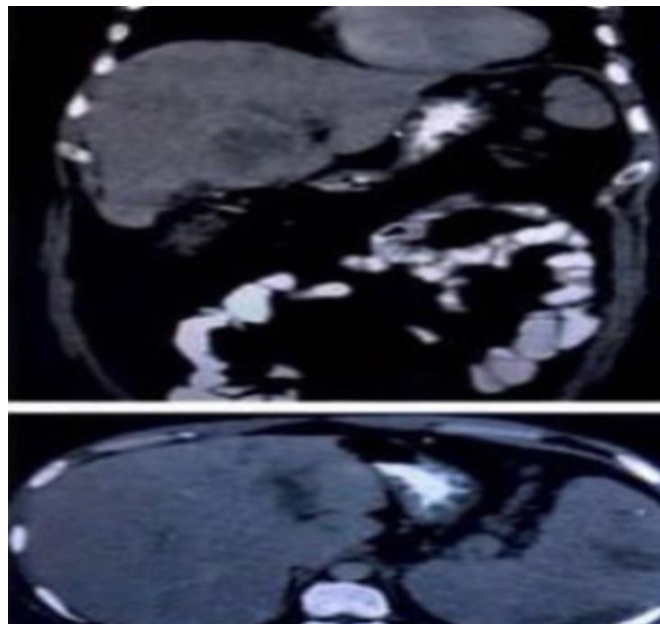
Contrast-enhanced CT of the abdomen demonstrating multiple hepatic and splenic lesions with associated right lower-zone pulmonary consolidation.
